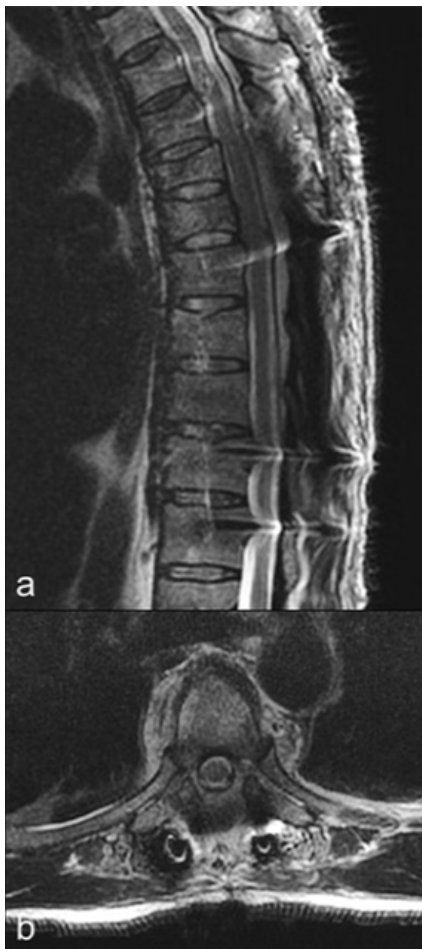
a) Sagittal and b) axial T2-weighted MR images show complete removal of the lipoma.
